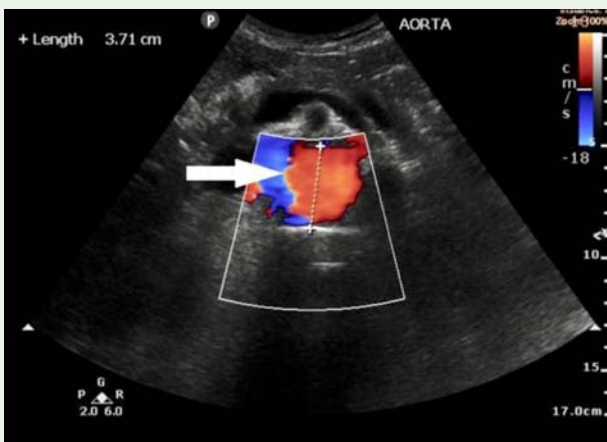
Ultrasound of the proximal abdominal aorta showing a dilated proximal abdominal aorta at 3.71 cm diameter, with a suspected flap (as indicated by the white arrow) seen within the lumen.
